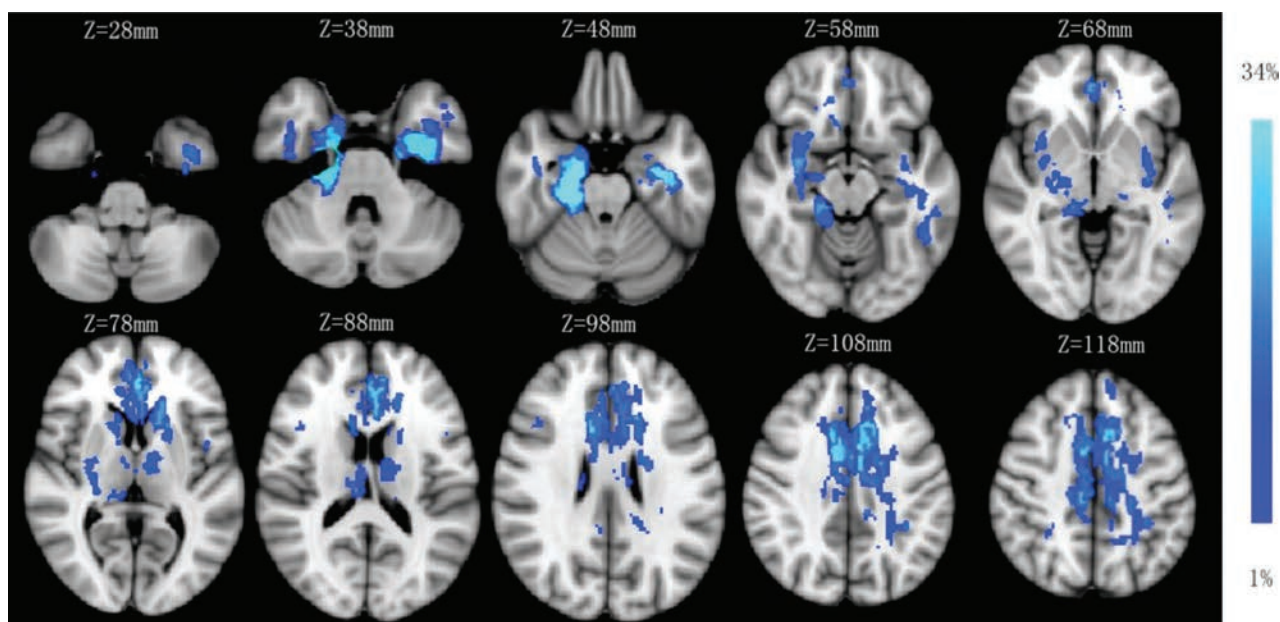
Lesion probability map of brain MR imaging. The mean lesion probability distribution thresholded at 34% is shown in light blue and thresholded at 1% is shown in blue and overlaid on the ICBM152 T1 template in the Montreal Neurological Institute space.
